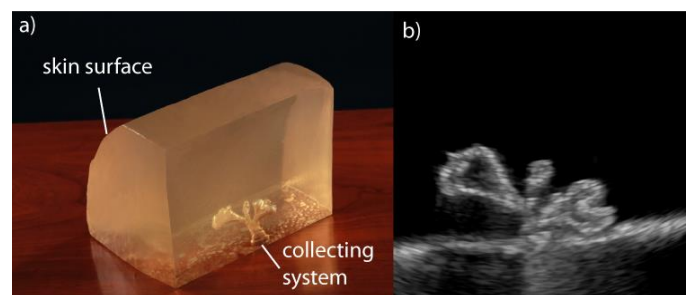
a) Gelatin based mockup, b) Ultrasound image of the water filled collecting system in the mockup
